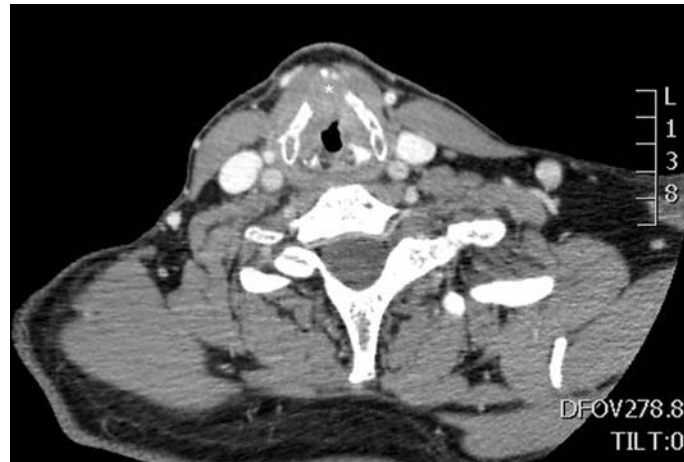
Axial contrast enhanced CT performed in a patient with a tumor invading the anterior commissure and penetrating through the cartilage.
